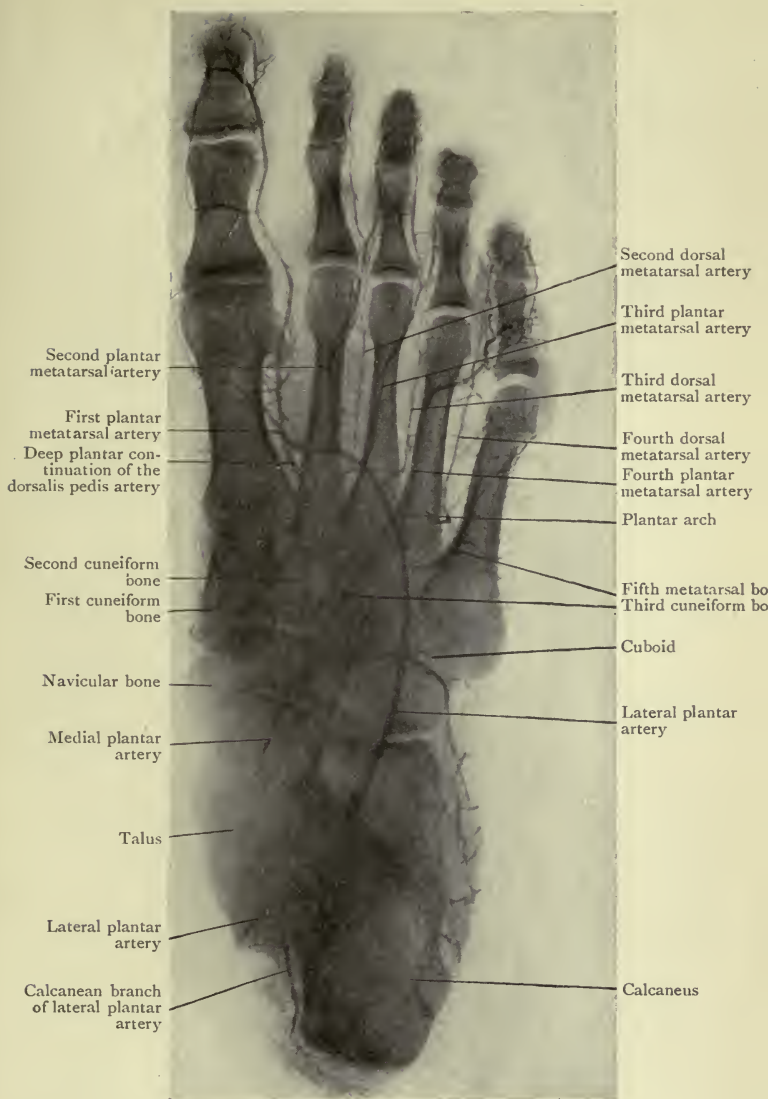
Radiograph of an Injected Foot showing the relations of some of the arteries to the bones.
